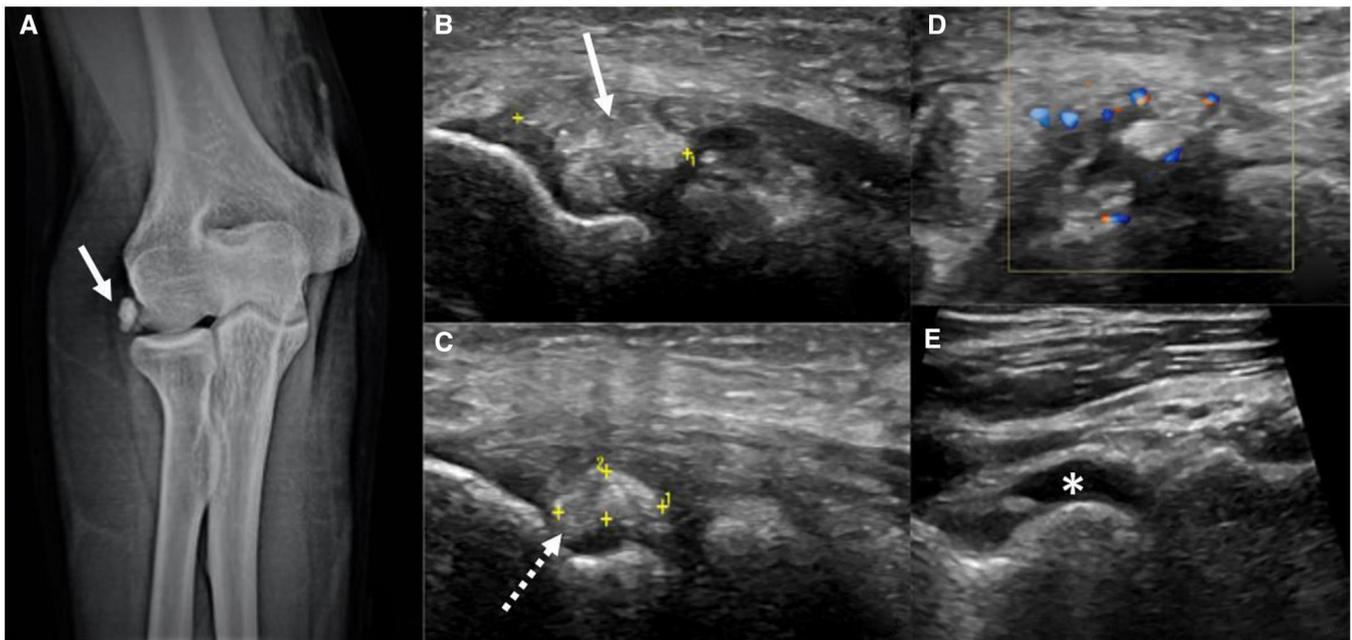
Conventional frontal radiograph of the elbow (A) showing amorphous calcific densities in the region of common extensor origin (white arrow) suggesting calcific tendinopathy. Corresponding ultrasound images in longitudinal plane (B, C, and E) and in transverse plane (D) showing type II/III calcification in the common extensor tendon (white arrow), calcium migration can be seen through the deficient radial collateral ligament (dashed arrow) with adjacent neovascularity (D) and reactive radiocapitellar joint effusion (asterisk) suggesting ongoing inflammation.
